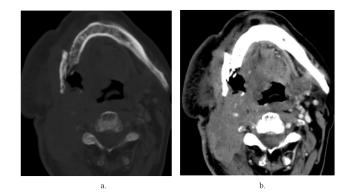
(case 13). SCC mandibular invasion in a 57-year-old male patient. (a) Bone window and (b) soft tissue window in axial contrast-enhanced neck computed tomography, starting from the floor of the mouth on the right and extending posteriorly to the paraspinal muscle planes and the inferior part of the occipital bone, destroying the right half of the mandible corpus, invading the carotid artery and jugular vein, and narrowing the air passage with malignant mass lesion.
